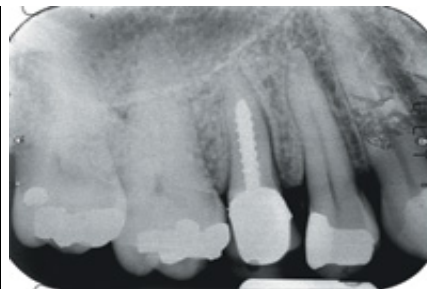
Pretreatment radiograph of class IV fracture.
